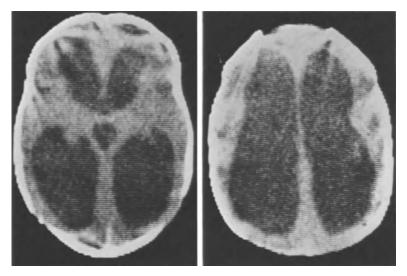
Rapidly developing hydrocephalus (CT Nov. 10, 1978)
